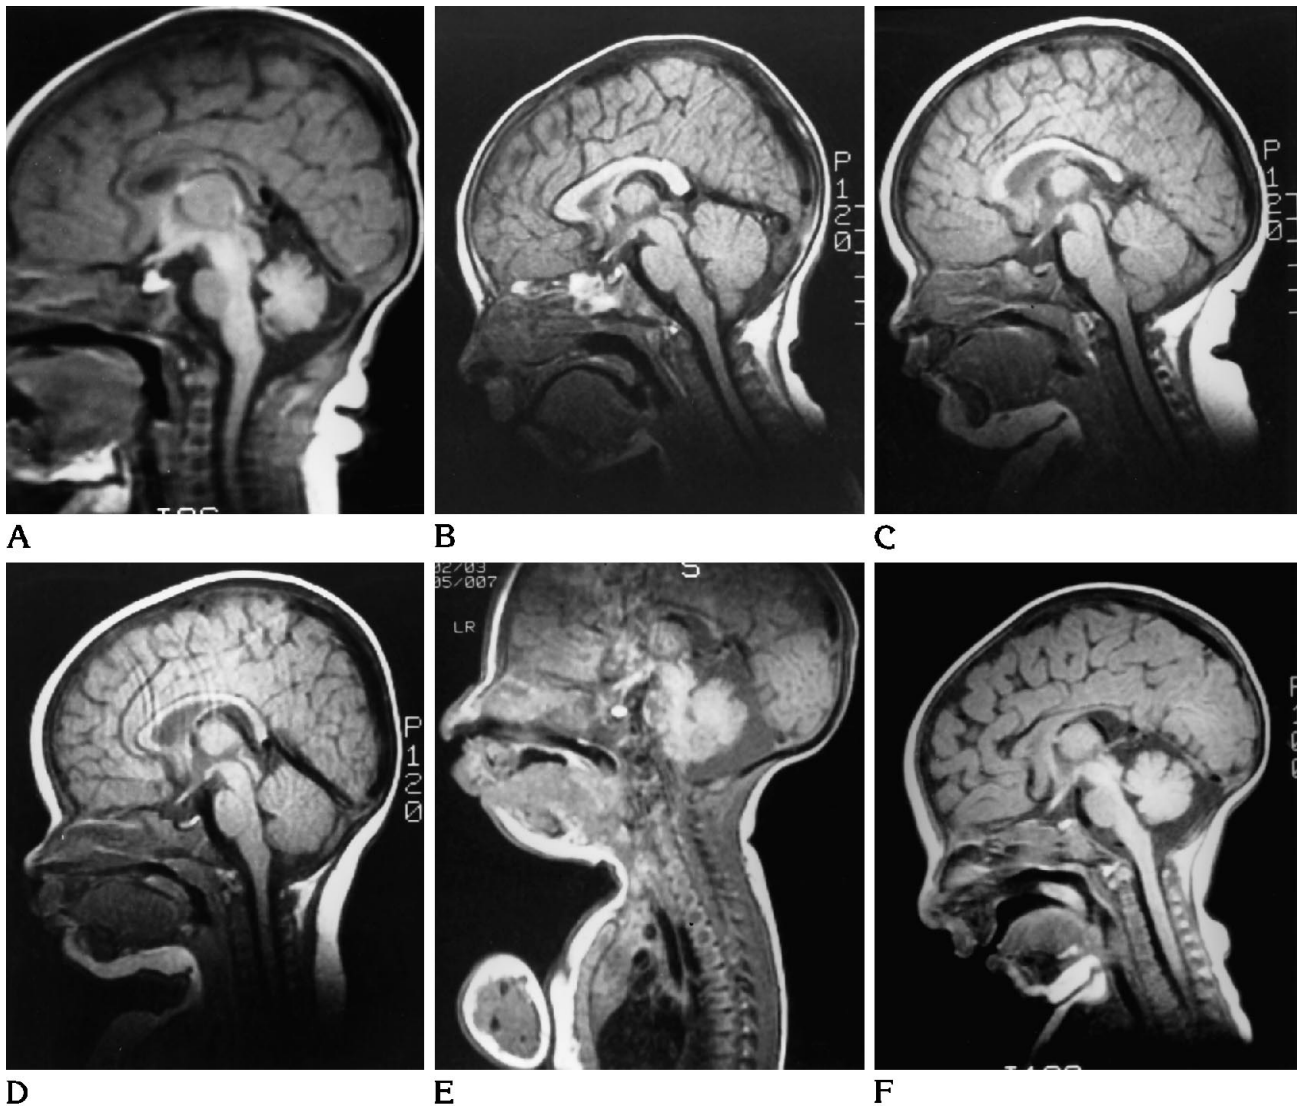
Grading criteria for the signal intensity and shape. Sagittal T1-weighted MR images (spin-echo 600/20) of the pituitary gland. A, Grade 3 anterior/grade 3 posterior pituitary gland with a convex superior surface. B, Grade 1 anterior/grade 3 posterior pituitary gland with a bimodal superior surface (hourglass-shape gland). C, Grade 1 anterior/grade 1 posterior pituitary gland with a flat upper surface. D, Grade 1 anterior/grade 3 posterior pituitary gland with a concave superior surface. E, At 8 days of age, grade 3 anterior/grade 3 posterior pituitary gland with a convex superior surface. F, At 6 weeks of age the pituitary gland demonstrates a grade 2 anterior/grade 3 posterior signal intensity and has a bimodal superior surface.
